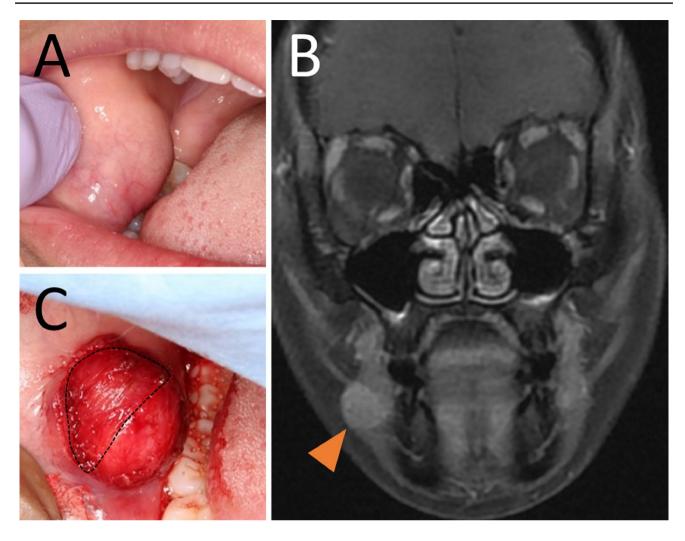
Clinical presentation. a Intra-oral finding. b Contrast-enhanced T1-weighted magnetic resonance imaging (MRI) in coronal view. c Surgical finding (dotted line indicated the buccinator)
